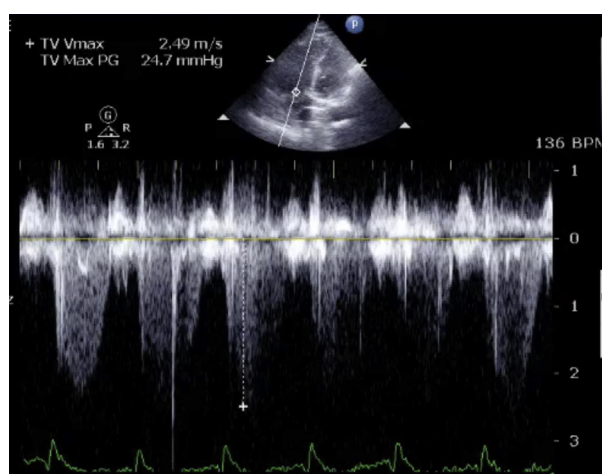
Apical four-chamber view with continuous wave Doppler interrogation of tricuspid regurgitation. The pulmonary artery systolic pressure can be estimated by the velocity of the tricuspid regurgitation jet. The relationship $4v^2 + \text{right atrial pressure (central venous pressure)}$, which is the right ventricular systolic pressure, is equal to the pulmonary artery systolic pressure as long as there is no pulmonic stenosis or right ventricular outflow tract obstruction.
